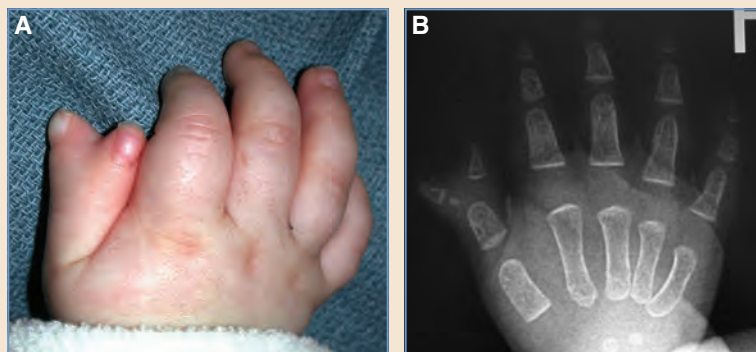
A Wassel type II duplication. A, Fully formed distal phalanges. B, The radiographic appearance.
